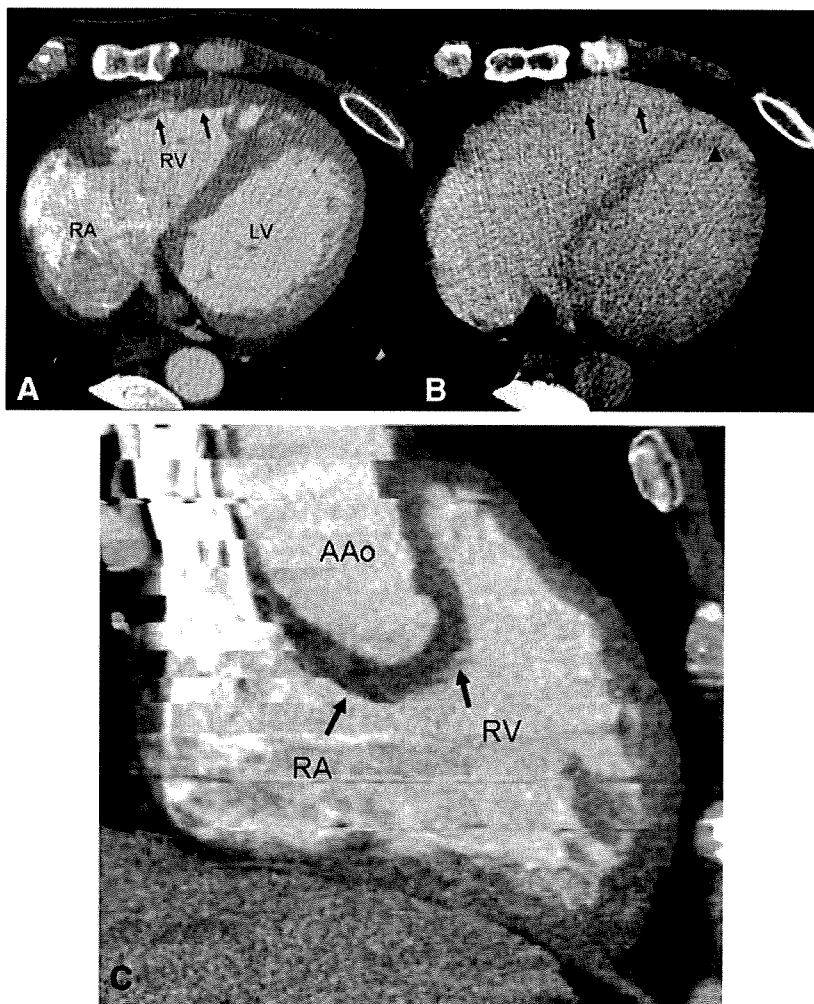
Axial source (A and B) and multiplanar reconstruction images (C) of enhanced multislice computed tomography revealed thickening of the right atrial (RA) and RV free walls (arrows in A and C) and part of the LV wall, which were abnormally enhanced in the later phase, as well as part of LV (arrows in B), suggesting lymphocytic infiltration and edema. AAO indicates ascending aorta.
